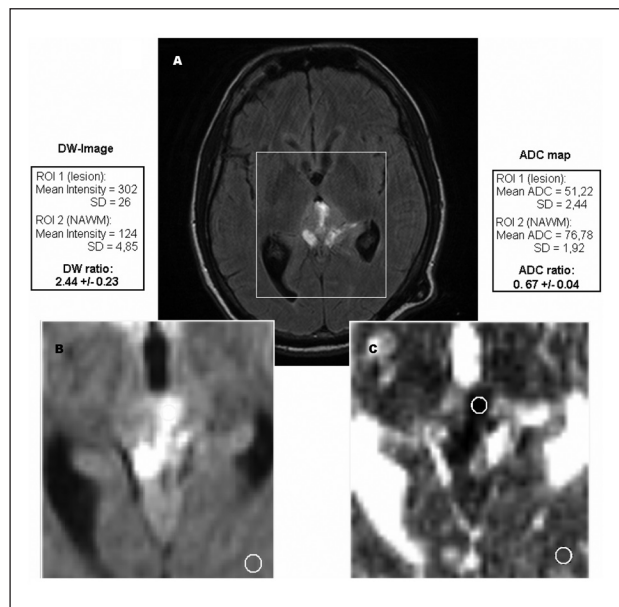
MR Imaging before treatment: (A) FLAIR demonstrates the hyperintense pineal mass. (B) DW image shows high signal in the lesion and a DW ratio of 2.43. (C) ADC map confirms the area of restricted diffusion and a mean ADC ratio of 0.67.
